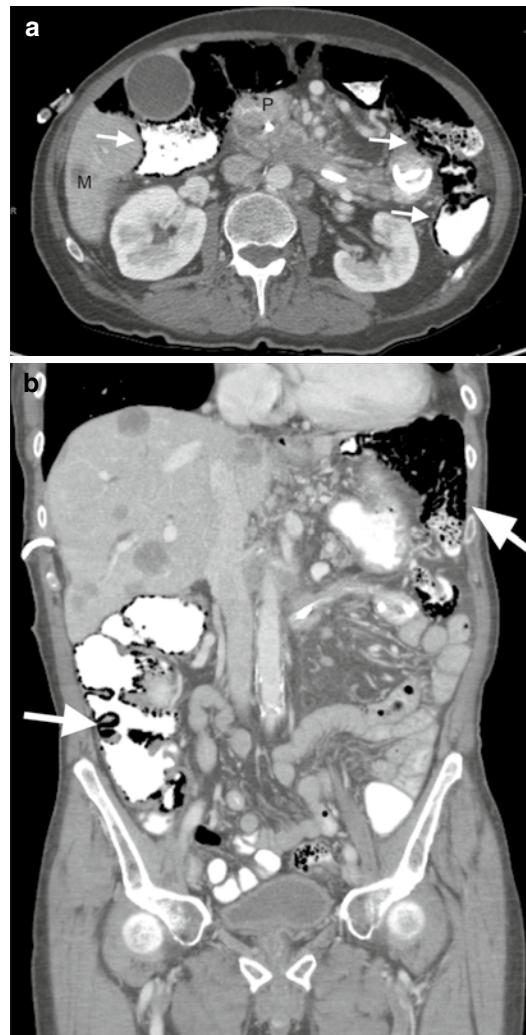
Pneumatosis intestinalis due to folinic acid, 5-FU, and oxaliplatin (FOLFOX). A 74-year-old male with pancreatic cancer with liver metastases treated with FOLFOX presented for follow-up imaging. Axial (a) and coronal (b) CT shows the pancreatic malignancy (P) with stent in place and liver metastatic disease (M). There is interval development of air cysts within the colonic wall (arrows). This can be an incidental finding on restaging imaging, but the clinician should be notified of this finding to ascertain the patient is asymptomatic
